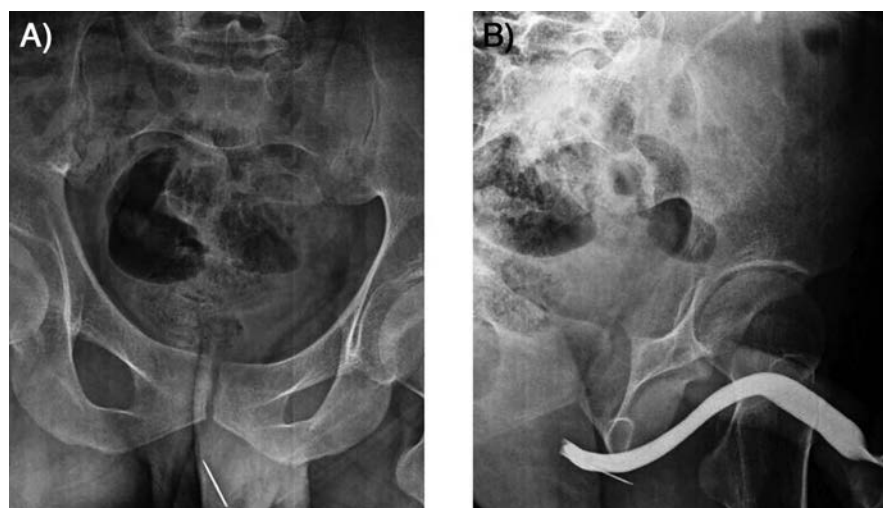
Tapestry needle is at proximal penile urethral localization in pelvic X-ray graph (A) and it was confirmed with retrograde urethrography (B).
